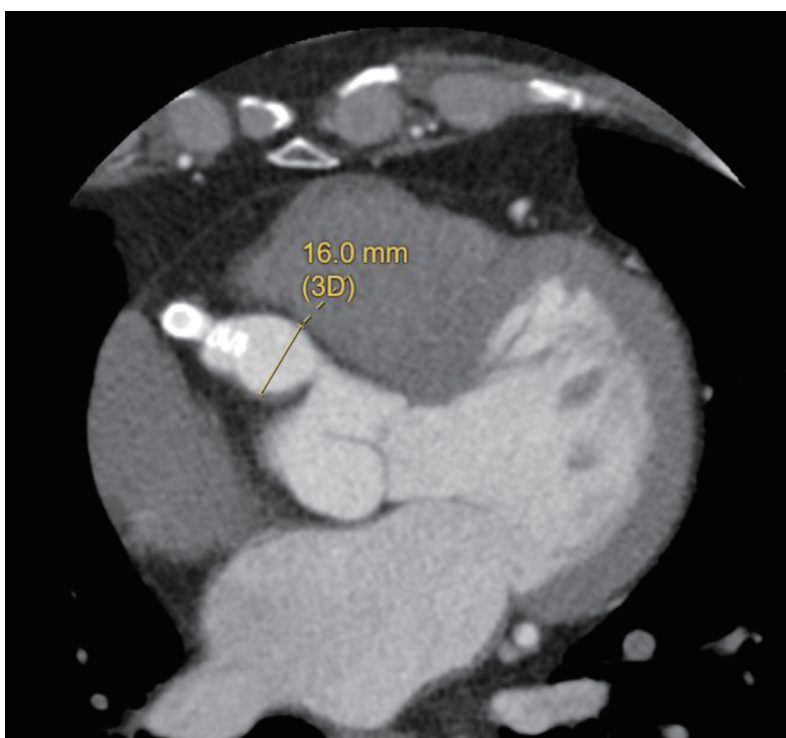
Regarding the aneurysm, representative computed tomography (CT) image showed a 16 mm measured diameter; full CT assessment measured $1.5 \times 2.1 \times 1.6$ cm.
